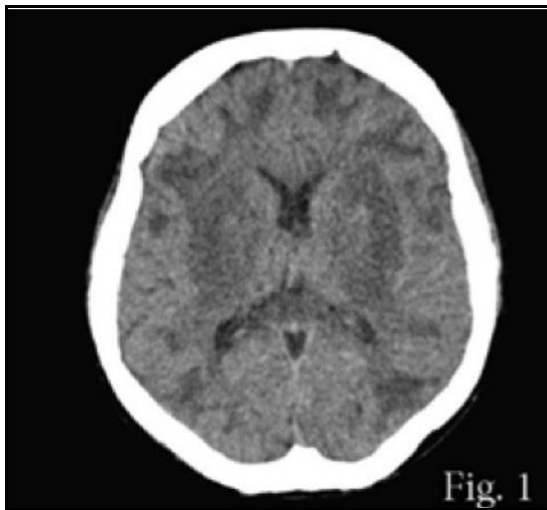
Plain CT brain showing bilateral symmetrical low attenuation at both putamen selective of putaminal necrosis with high attenuation at bilateral putaminal foci (attenuation ranging from 50 to 55 HU) due to putaminal haemorrhage.
